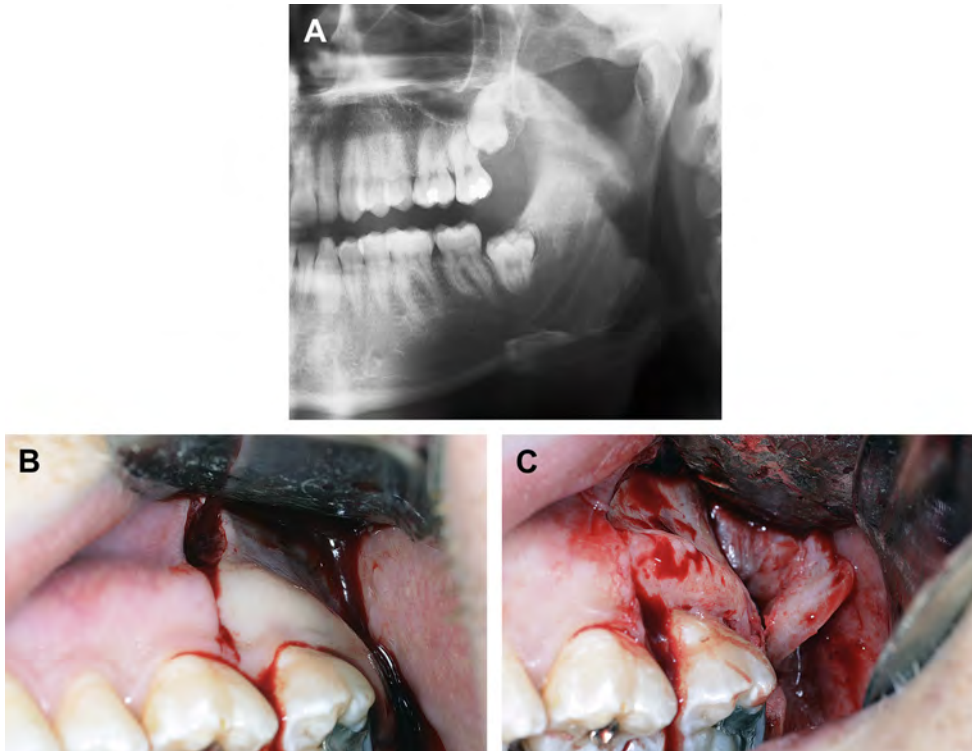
(A) Radiograph of impacted maxillary left third molar. (B) Three-cornered flap with releasing incision to access deeply impacted third molar. (C) Three-cornered flap soft tissue reflected.
